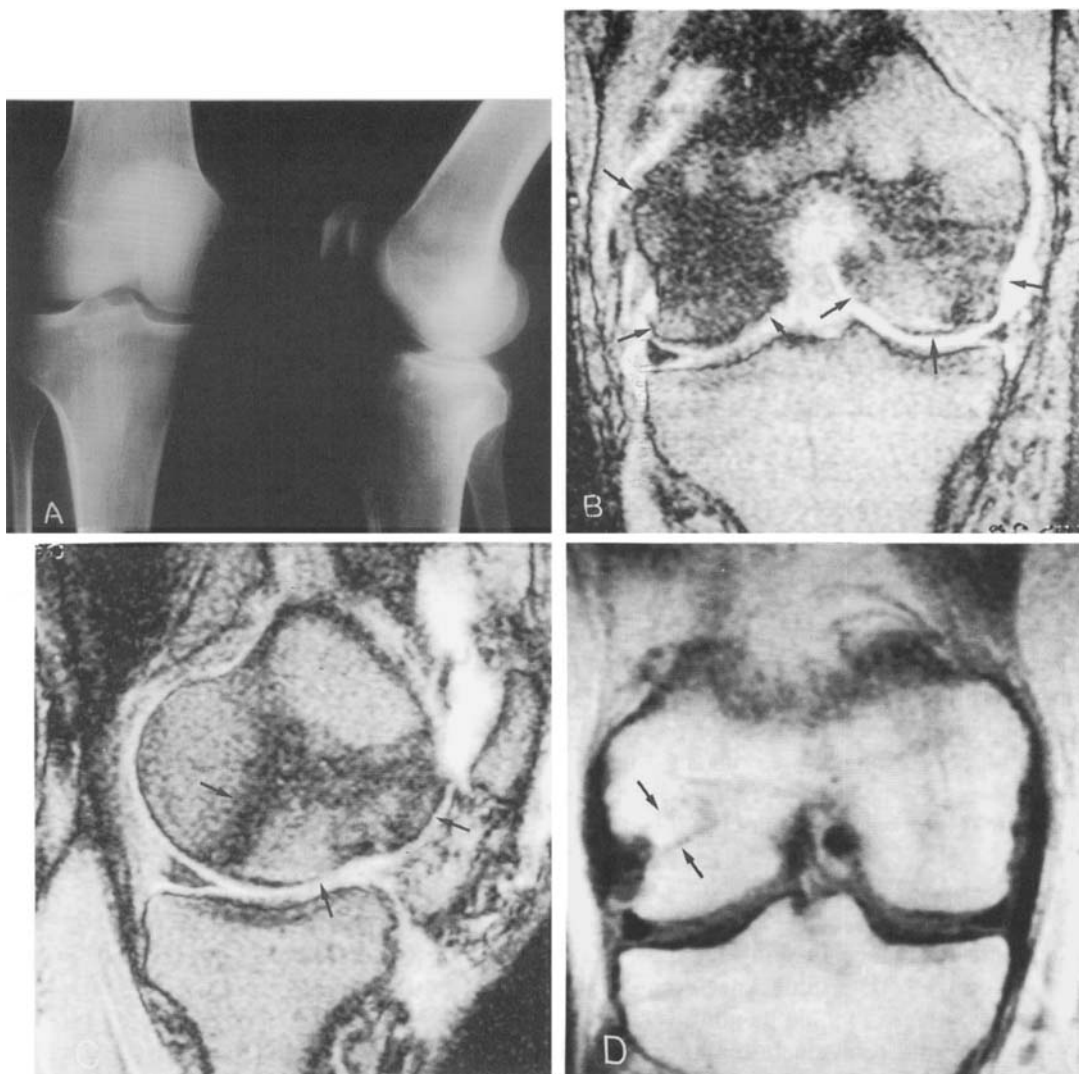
(A) Normal preoperative anteroposterior and lateral radiograph of the knee in a 19-year-old man. (B) Preoperative coronal MRI demonstrates osteochondritis dissecans of the medial and lateral femoral condyle and of the proximal tibia (arrows). (C) Preoperative sagittal MRI showing osteochondritis dissecans of the lateral femoral condyle (arrows).
